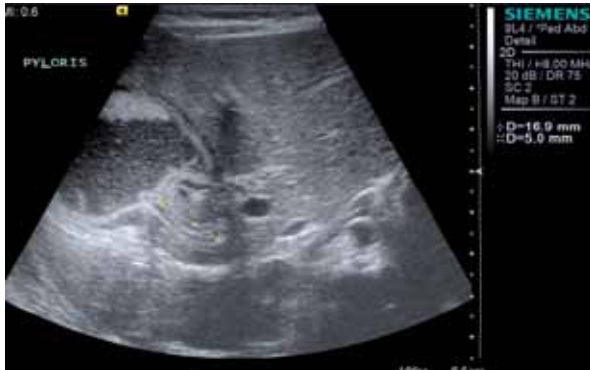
Ultrasound features of pyloric stenosis.
